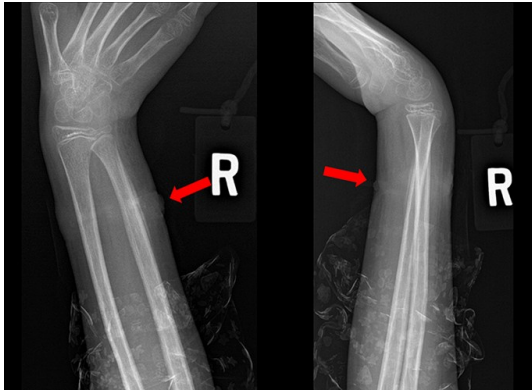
Right wrist x-ray showed soft tissue constriction and periosteal reaction (red arrows).
